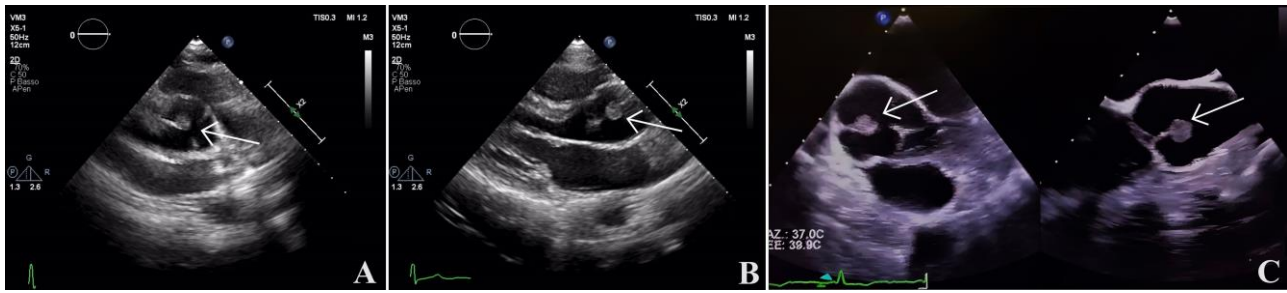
Trans-thoracic echocardiogram (TTE) revealed a floating round-shaped hyperechoic mass with shimmering borders on the aortic valve (arrows) in (A) parasternal long axis (PLAX) and (B) parasternal short axis (PSAX) views. These findings were then confirmed by trans-esophageal echocardiogram (TEE) (C).
